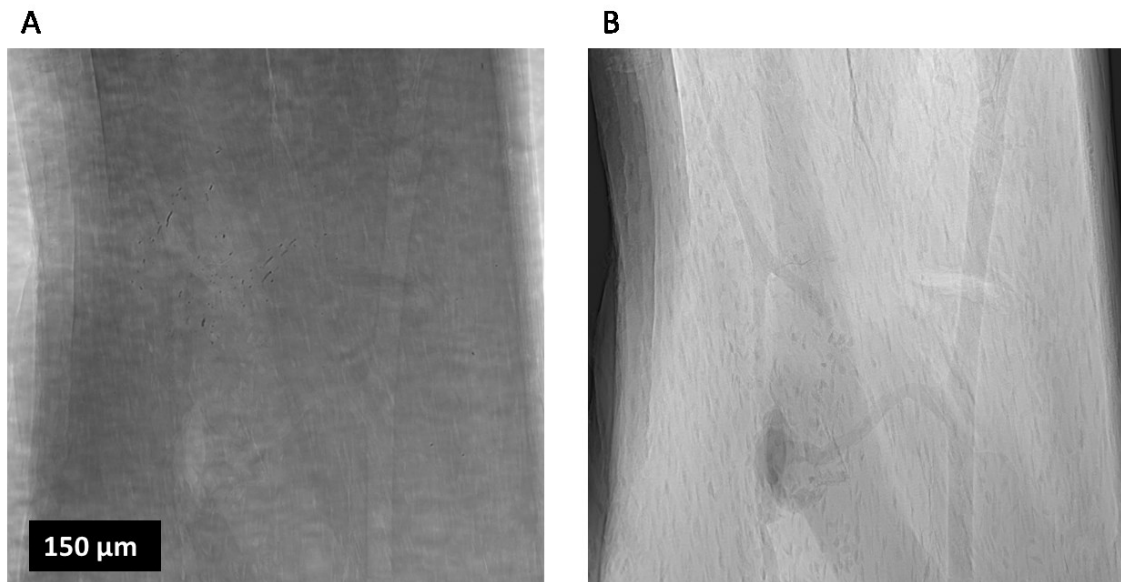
A: Phase contrast radiograph through a cortical piece of bone measured on ID19, pixel-size 300 nm, $E=19$ keV, $d\sim 10$ mm. B is the same image after flat-field correction ($\log(I_0\text{-dark}/I\text{-dark})$).
